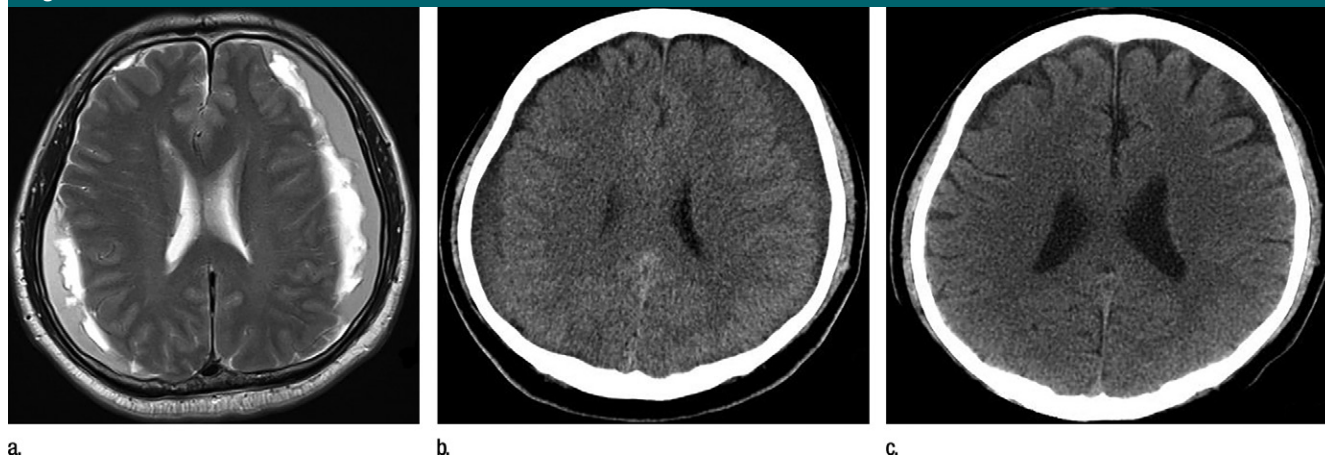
Images in a 77-year-old man with asymptomatic bilateral CSDHs receiving MMA embolization without burr-hole drainage. (a) Preembolization axial T2 image shows laminar-type chronic hematomas occupying left frontotemporoparietal and right frontoparietal areas (maximum hematoma width: left, 24.7 mm and right, 19.5 mm). (b) Axial nonenhanced CT scan obtained 3 months after embolization shows decrease in maximum width (left, 12.7 mm; right, 10.6 mm) and relevant mass effect of hematoma. (c) Six-month follow-up axial nonenhanced brain CT scan shows complete resolution of hematoma.
